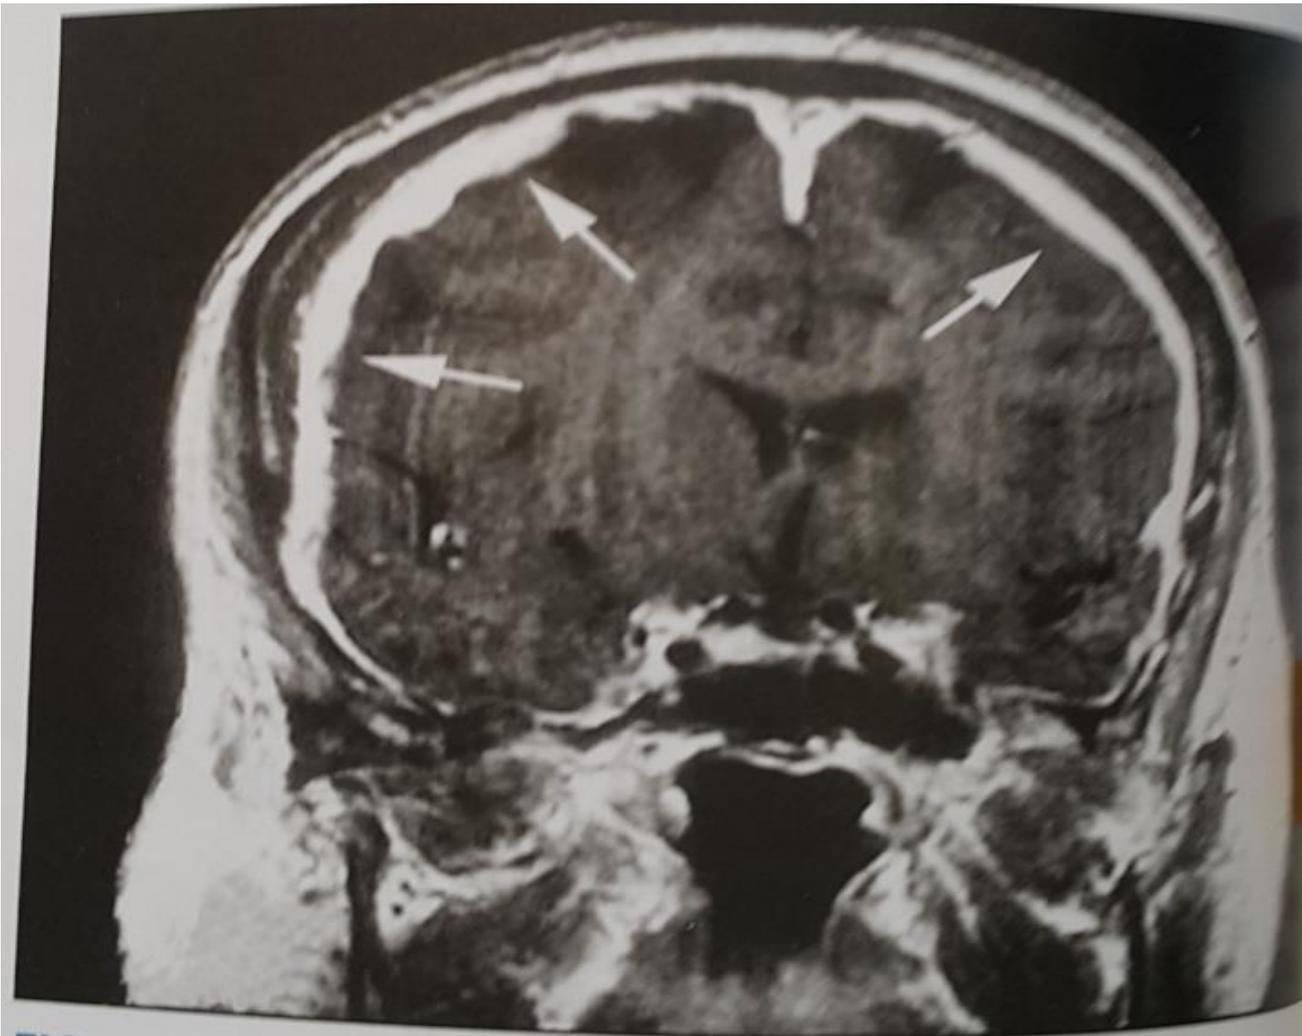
Intracranial hypotension. Gadolinium-enhanced MRI scan of a patient with intracranial hypotension. There is widespread, symmetric meningeal enhancement (*arrows*).
